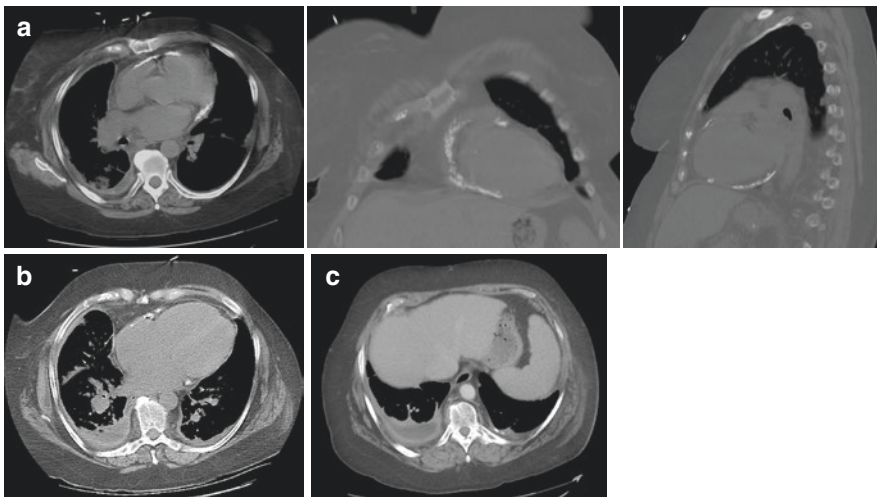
Computed Tomography showing pericardial calcification (a), bilateral atrial enlargement (b), and dilation of the inferior vena cava (c) in a patient with constrictive pericarditis
